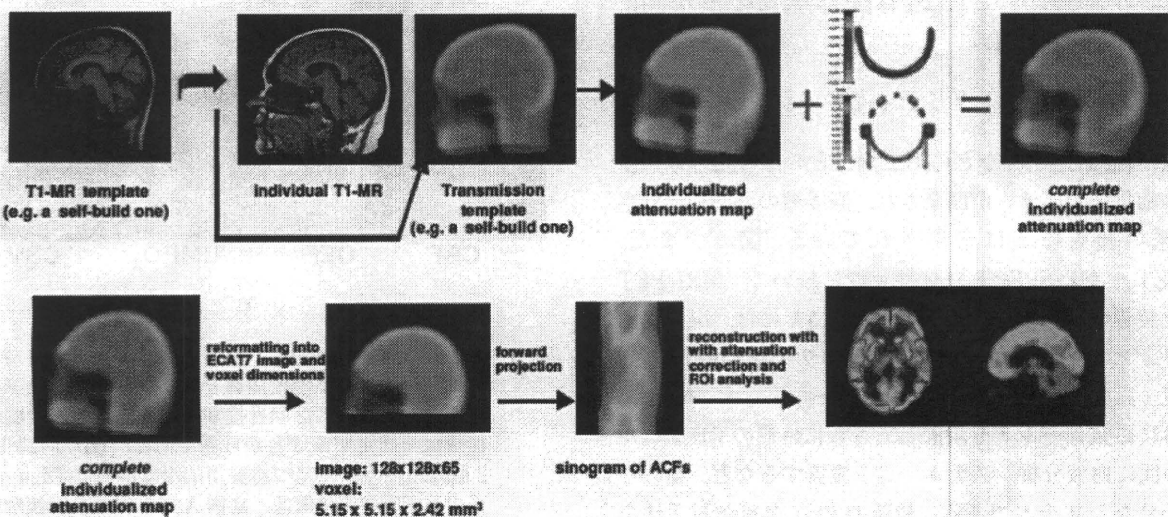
MRI-PET一体型装置におけるMRIデータを使った吸収補正法の一例。予めデータベース化したトランスミッションデータを、MRI撮像データをもとに個々の症例に非線形に一致させる。これにヘッドレストやRFコイルなどの吸収を発生させる構造を付加させる。
